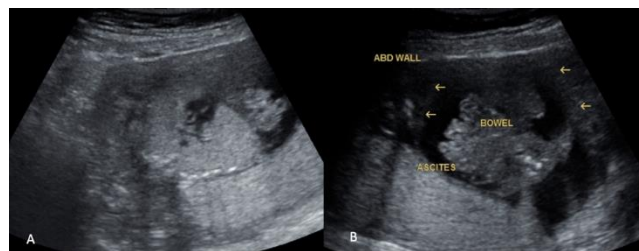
Ultrasound image of the fetus with congenital high airway obstruction syndrome at 18-19 weeks of gestation. (A). Dilated trachea behind the great vessels. (B). Ascites with free floating bowel loops.
